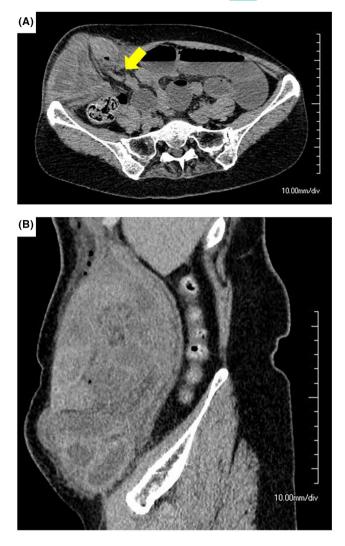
Preoperative images of port-site hernia. Horizontal image (A) and sagittal image (B) of plane computed tomography. The patient developed a huge palpable mass and sudden right lower abdominal pain on postoperative Day 5. Computed tomography revealed a $163 \times 91 \times 63$ mm mass. Herniation of the small bowel through the port site was suspected. Yellow arrow indicates the 12-mm port site. (Scale bar: 1 cm/ division of scale).
